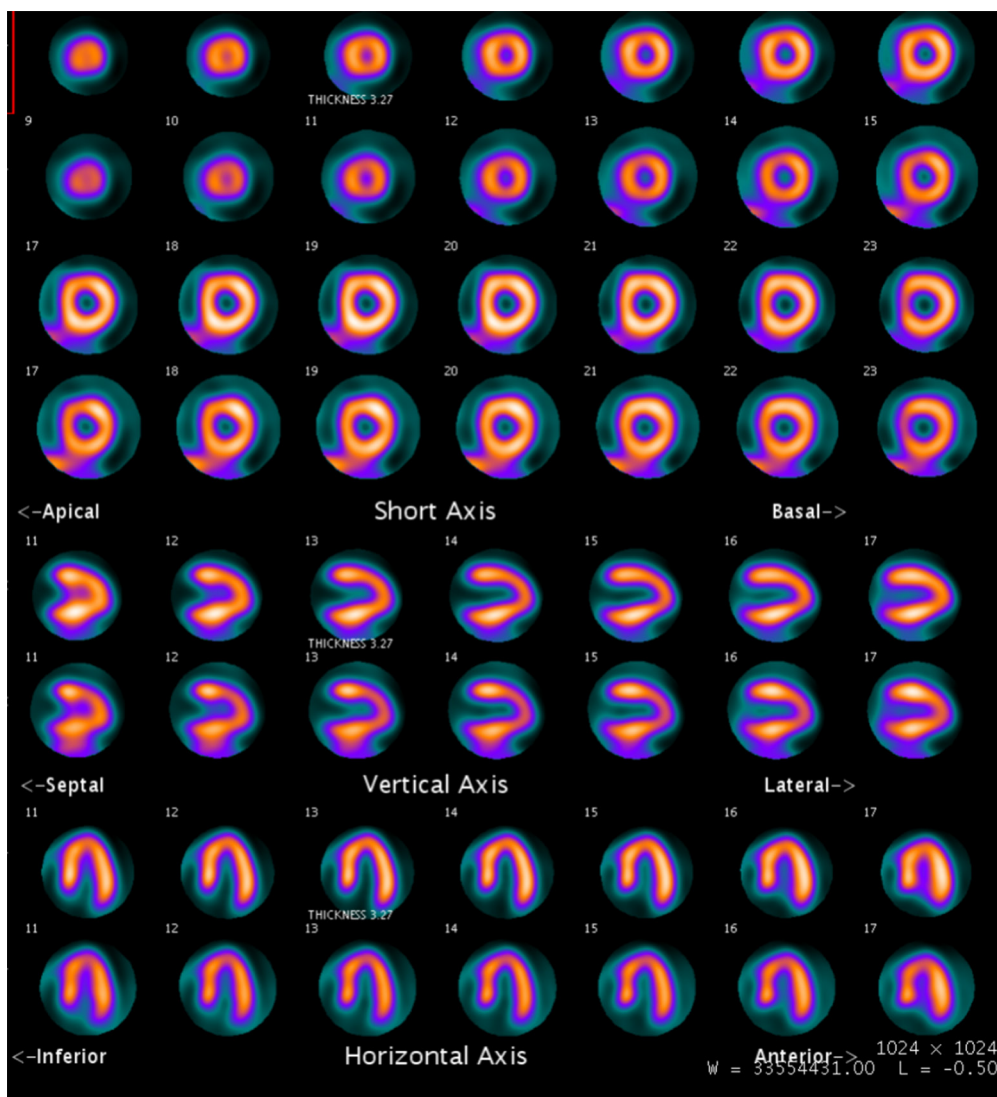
Normal adenosine-stress ¹³N-ammonia positron-emission computed tomography myocardial perfusion (PET-CT MPI) images. The images demonstrate normal and homogenous radiotracer distribution in both the rest and stress images throughout the left ventricle.
